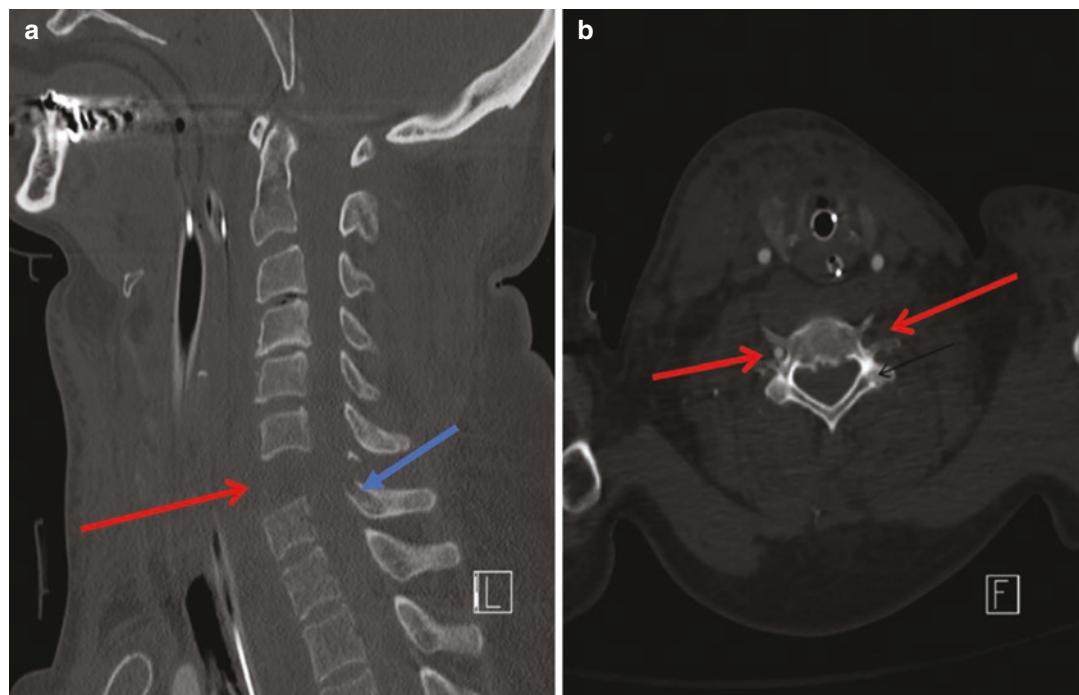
CT cervical spine (a) sagittal reformation shows flexion distraction with complete avulsion of the C6/C7 interspace, with disc space widening of approximately 1.5 cm (red arrow). There is also an associated fracture through the superior endplate of C7 extending
